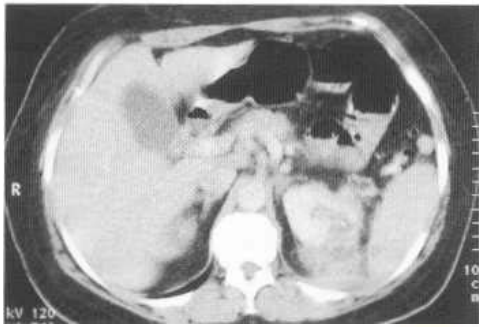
Perinephric abscess on CT. There is an adjacent area of severe renal parenchymal inflammation with a tiny associated calculus. A small reactive pleural effusion is also present.
